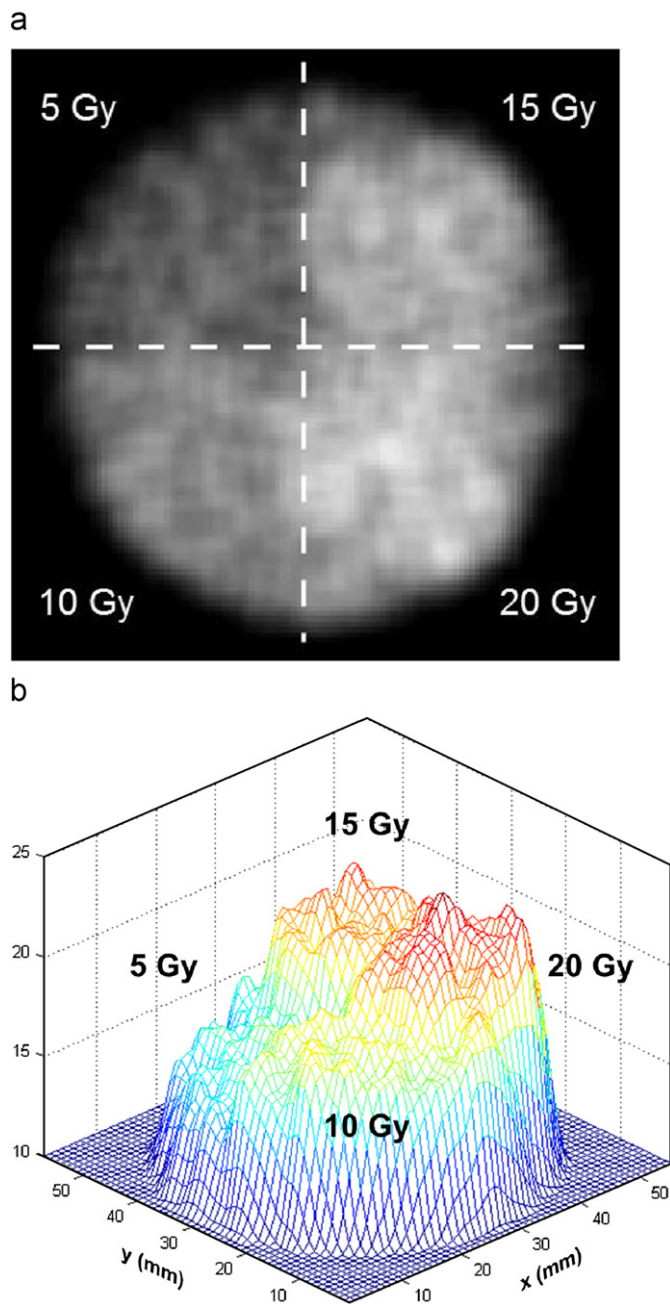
(a) CT image and (b) corresponding mesh image of the culture dish with four quadrants subjected to doses of 5, 10, 20, and 15 Gy counterclockwise. The four regions of the dish can be well distinguished.
